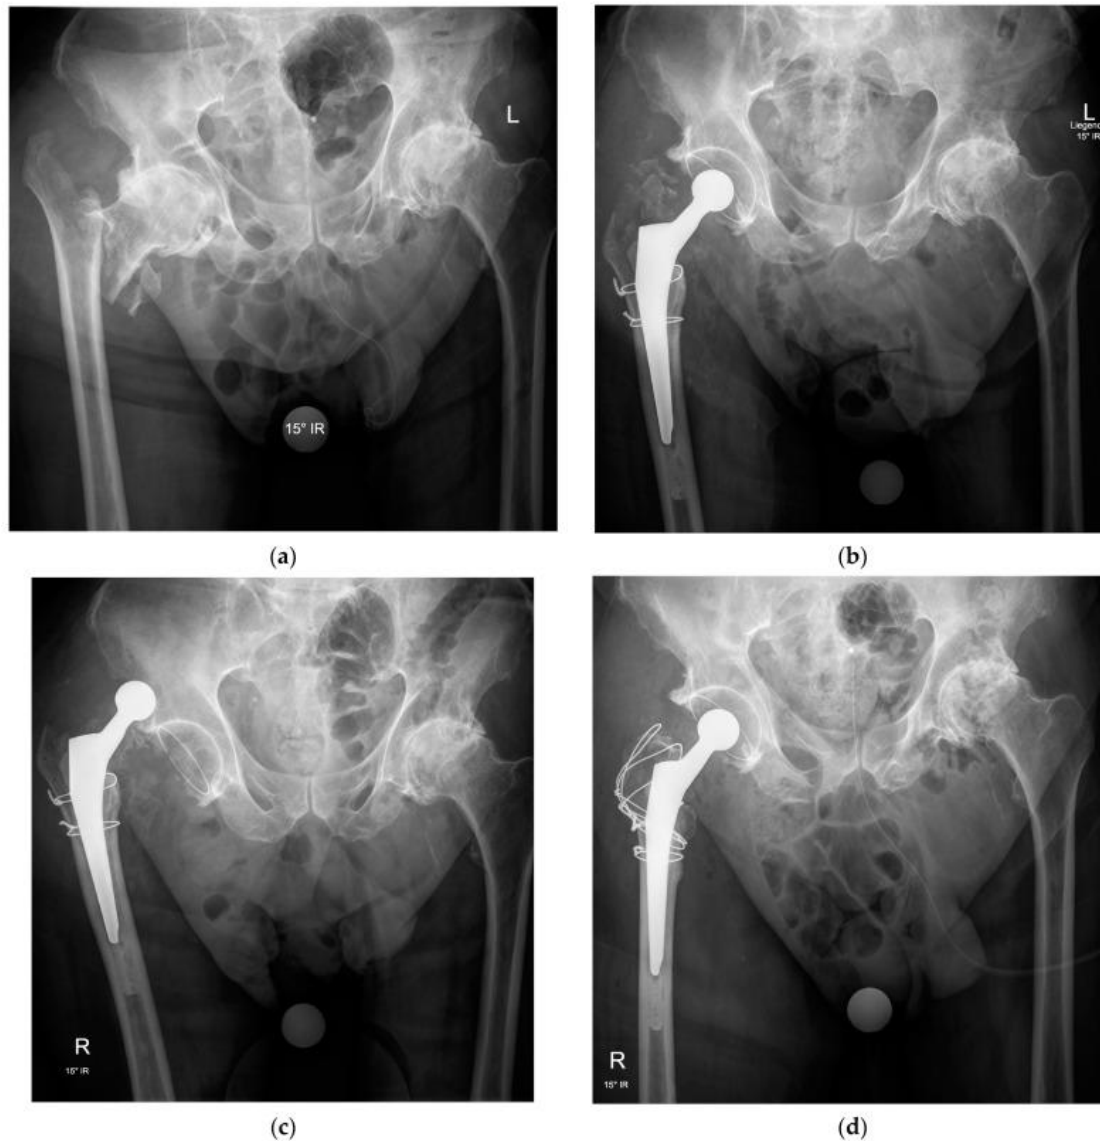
Anteroposterior pelvic radiographs of an intertrochanteric fracture with advanced osteoarthritis (a) treated by total hip arthroplasty with a cemented femoral stem, a cemented acetabular cup, and two wire cerclages to stabilize the metaphyseal fragments around the femoral stem but without fixation of the greater trochanter (b), resulting in recurrent dislocations in the early postoperative period (c) and requiring revision surgery for fixation of the greater trochanter by a figure-of-eight wire cerclage technique allowing restoration of hip stability and healing of the fracture fragments in a good position with no further dislocation (d).
